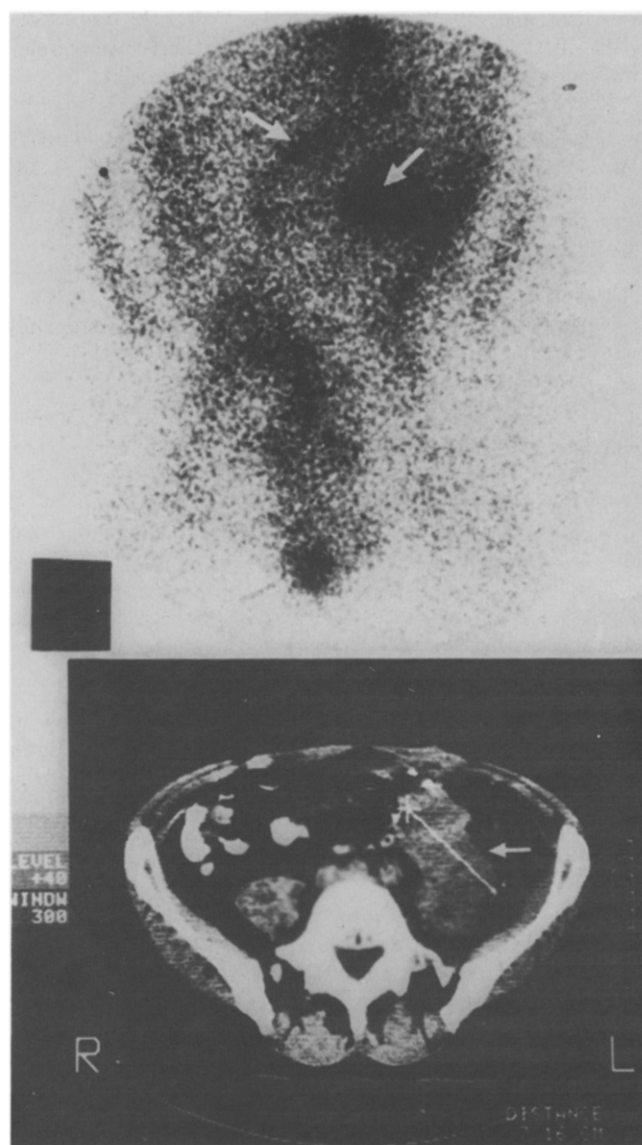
[ $^{125}\text{I}$ ]H17E2 MAb scan 3 days after injection shows uptake in lower paraortic and left iliac lymph nodes (upper panel), which correlates with the mass in the left iliac region shown in the CT scan (lower panel).
